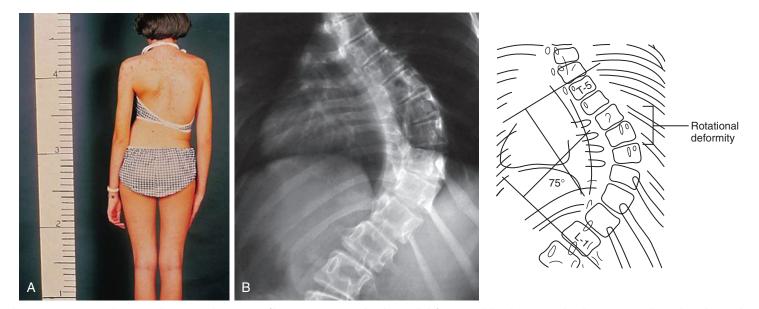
Severe thoracic scoliosis secondary to neurofibromatosis. A, Note the chest wall deformity and that the patient's head is not centered over the pelvis. B, The severe curvature is more apparent on this radiograph. The angle of measurement (here, 75 degrees) is determined by the intersection of lines drawn perpendicular to the vertebrae at the ends of the curve (Cobb method).
